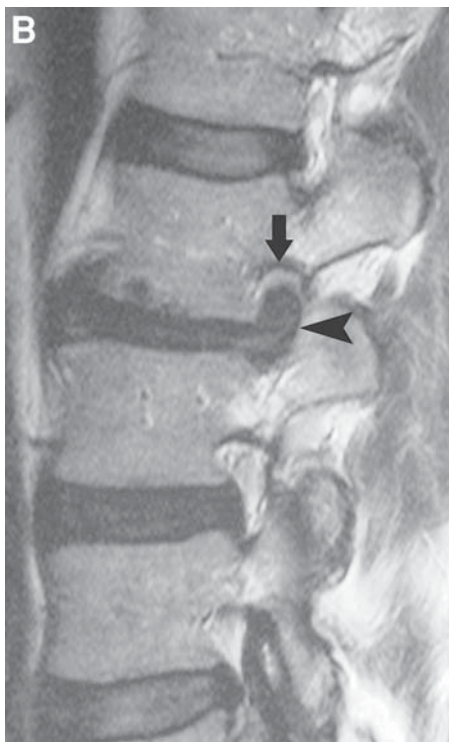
Disc extrusions. Sagittal T2-weighted image (A) demonstrates a large disc extrusion (*star*) that extends to the posterior aspect of the canal. Sagittal T2-weighted image (B) in a different patient demonstrates a superiorly migrating neural foraminal disc extrusion (*arrowhead*) which compresses the exiting nerve root (*arrow*).
